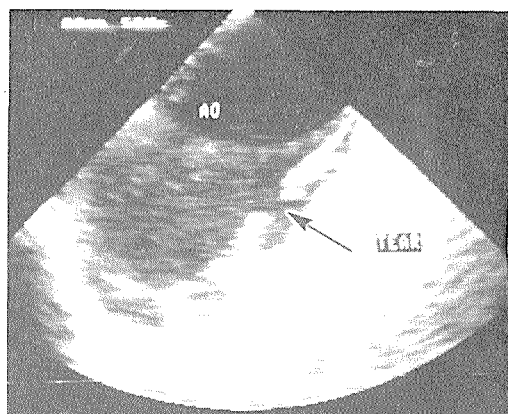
Cross-sectional transesophageal image of the aortic arch (AO) in a patient with acute dissection. The arrow shows the intimal tear. The color flow Doppler study confirms the flow at this site. Subsequent surgical inspection confirmed that this was the site of an intimal tear.
